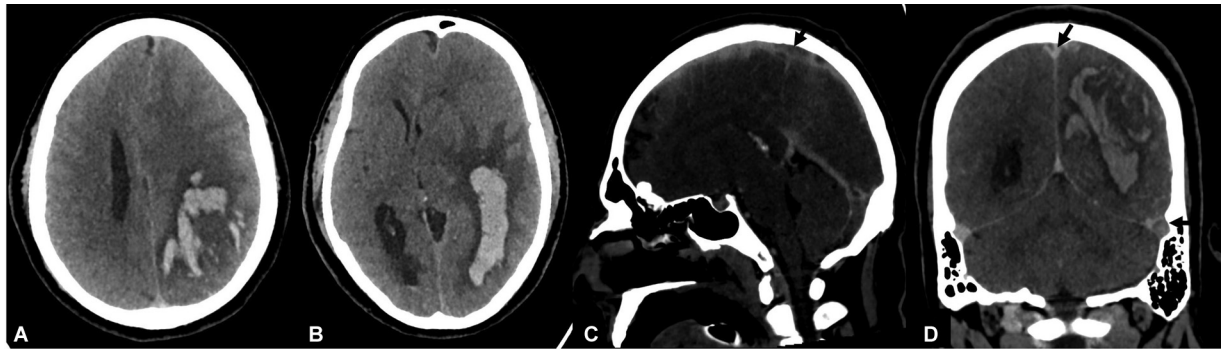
Cerebral venous sinus thrombosis with coronavirus disease 2019 (COVID-19) infection: 48 years/male presented with headache with fluctuating dysarthria on day 12 of COVID-19 infection. The noncontrast computed tomography (CT) scan (A and B) shows intraparenchymal hemorrhage at left parietotemporal region with moderate perilesional edema and mass effect. The contrast-enhanced CT (C and D) shows thrombus within the mid-third of superior sagittal sinus and the left transverse-sigmoid sinus (black arrow).
